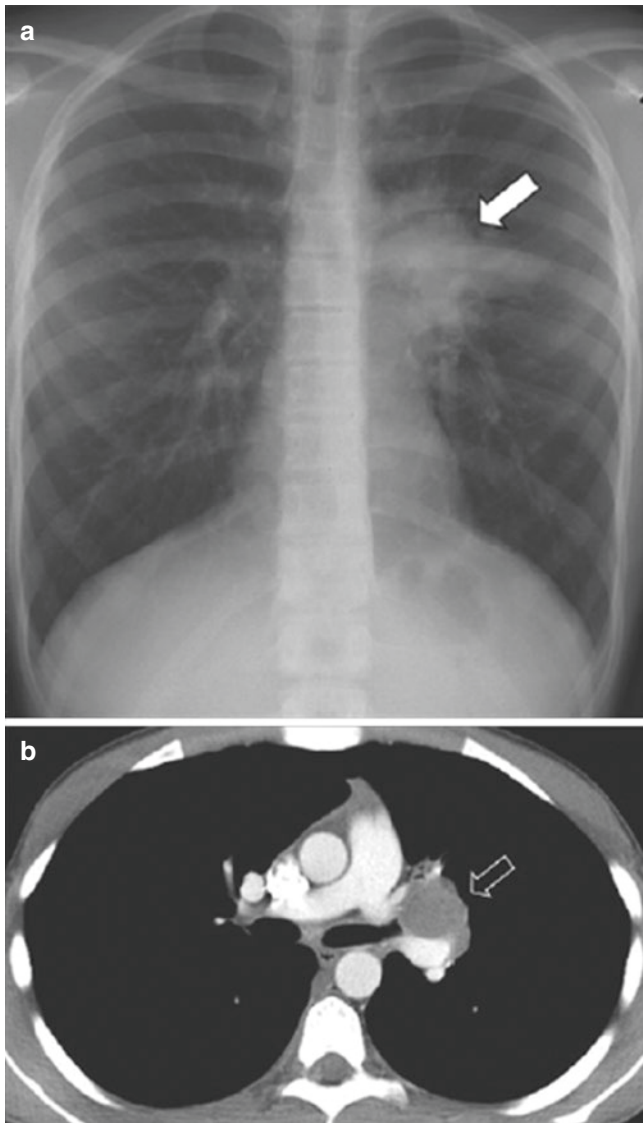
An 11-year-old boy who presented with respiratory distress. Surgical pathology of the left hilar mass was consistent with mucoepidermoid carcinoma. (a) Frontal chest radiograph shows a large mass-like opacity (*arrow*) in the left hilar region. (b) Enhanced axial CT image demonstrates a mildly enhancing soft tissue mass (*arrow*) located in the left hilar region
